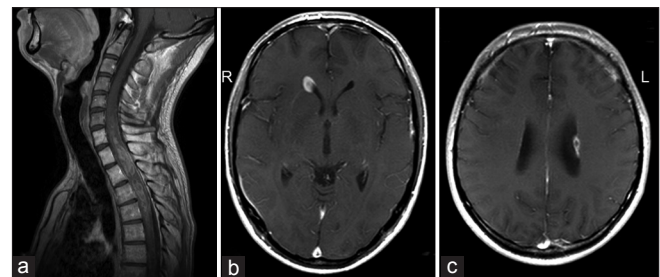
(a-c) Gadolinium-enhanced T1-weighted MR images showing an irregularly enhanced intramedullary lesion at the C6-T6 spinal level with enhancement along the dorsal surface of the spinal cord (a) and intracranial enhanced lesions located along the ventricular surface (b, c)
